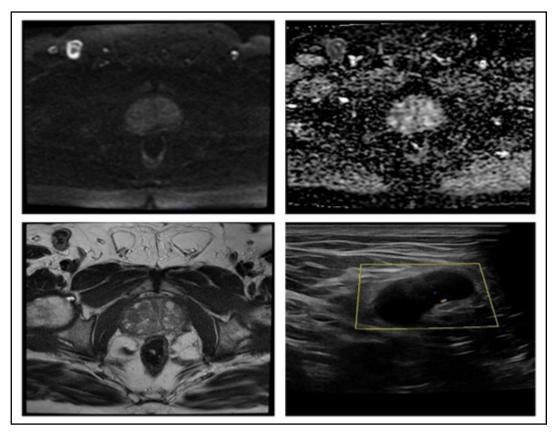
Multiparametric Prostate MR examination and ultrasound images of tuberculosis-associated inguinal lymphadenopathy
